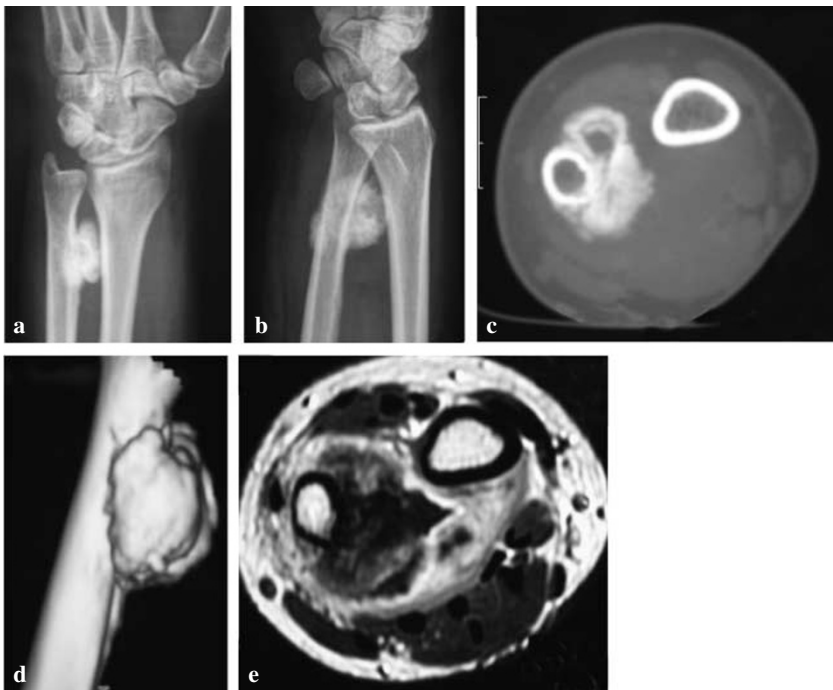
Diagnostic imaging of a parosteal osteosarcoma of the distal ulna. a, b Radiographs in anteroposterior (a) and oblique (b) projections showed a dense, inhomogeneous, calcified mass in the ventromedial part of the distal ulna. c, d Computed tomograms, without (c) and with (d) 3D reconstruction revealed a lobulated, calcified mass adjacent to cortical bone without infiltration of bone marrow. e MRI demonstrated the absence of neurovascular bundle involvement
